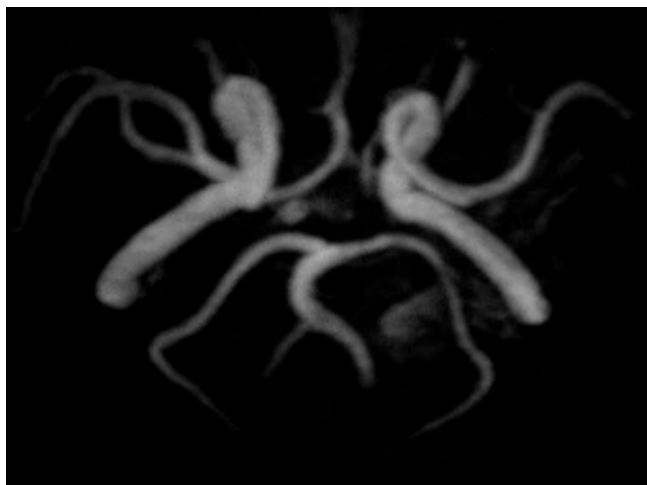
MRI angiographic reconstruction revealed no structural lesion in any cerebral vessel.
